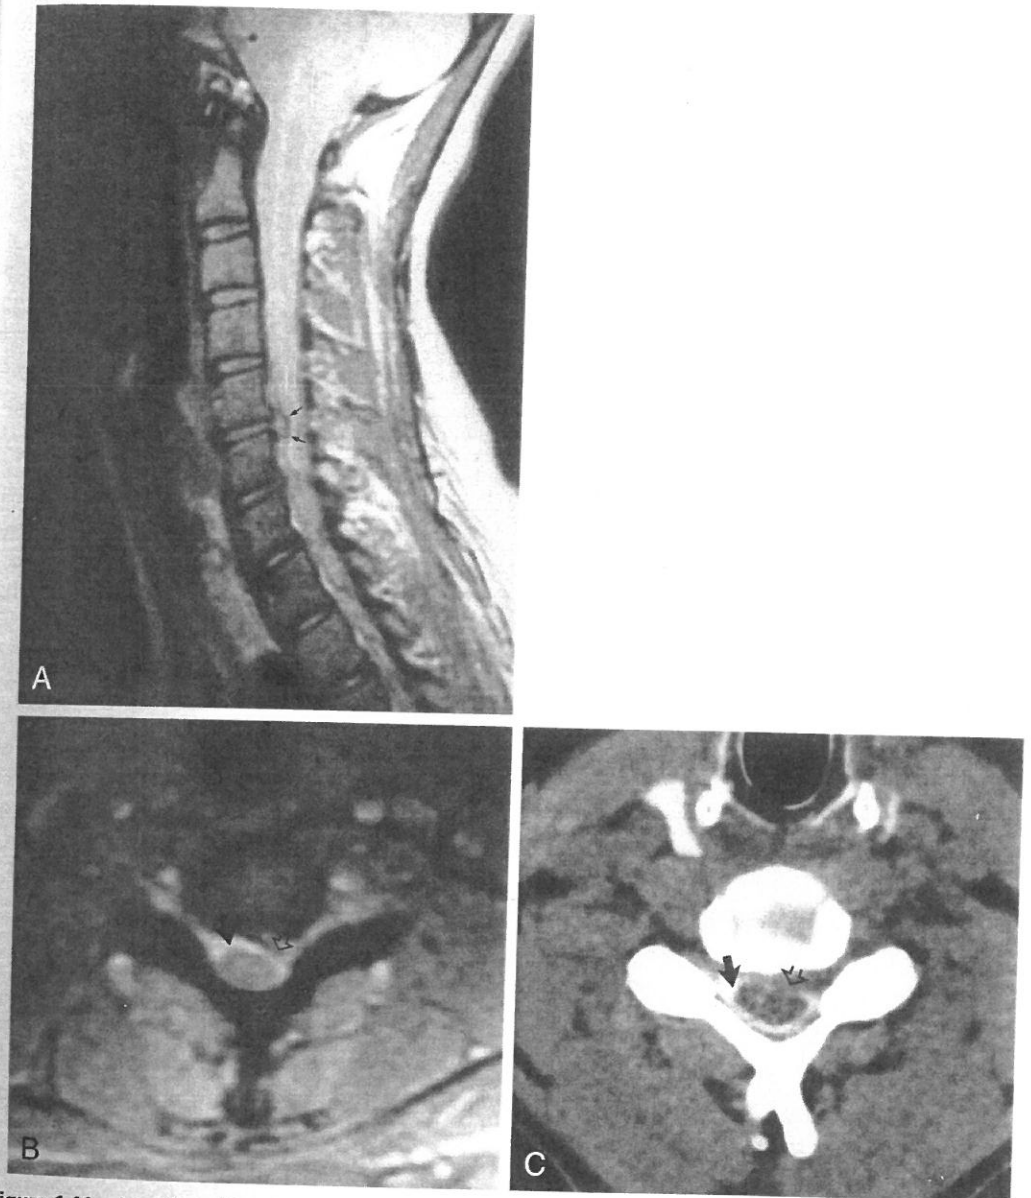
Imaging of herniated nucleus pulposus. *A*, sagittal MR proton density scan (TR 2118, TE 30) demonstrates posterior extrusion of disk material at C4-C5 (arrows). *B*, axial gradient echo image (TR 733, TE 18, flip angle = 13°) demonstrates high signal (white) to the normal cerebrospinal fluid (CSF) (solid arrow). Extruded disk material anterolaterally on the left (open arrow) effaces the CSF in this area and noninvasively clarifies the patient's cervical radiculopathy. *C*, axial CT-myelogram in a different patient with a similar herniated disc. The CSF shows high density (white) reflecting the instilled contrast material (solid arrow). This somewhat invasive study (myelogram) shows a similar pattern of anterior CSF effacement and cord distortion (arrows) compared with *B*.
